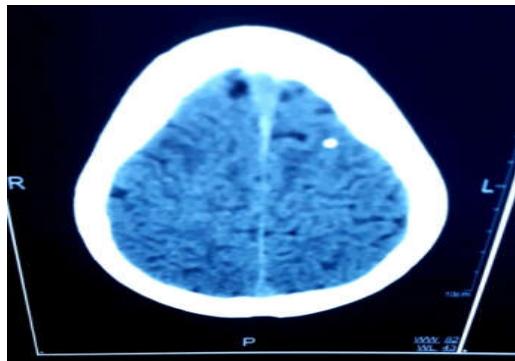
A single, small, contrast enhancing CT lesion: disc
